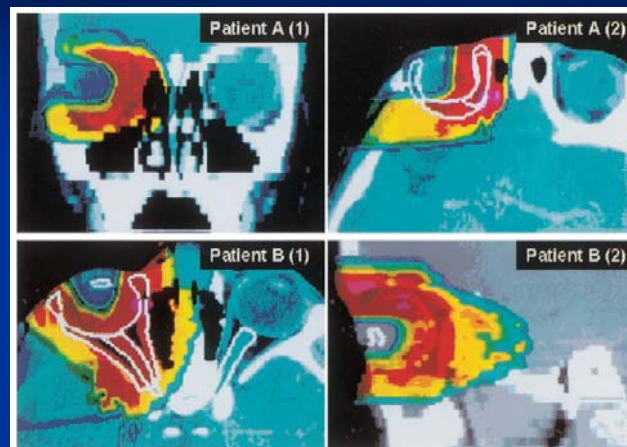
Patient A. Planning CT scan in coronal (1) and transverse (2) section with clinical target volume (CTV, medial and retrobulbar), gross tumor volume (GTV, medial structure) and nontarget lacrimal gland (lateral) contoured. Color display of dose distribution starting at 10 CGE (blue) with prescribed dose levels of 40 and 50 CGE to the CTV and GTV, respectively. Patient B. Planning CT scan in transverse (1) and sagittal (2) section with clinical target volume (CTV) and nontarget lens and optic nerves contoured. Gross tumor volume (GTV) is located superiorly and is not present on these representative sections. Color display of dose distribution starting at 10 CGE (blue) with prescribed
